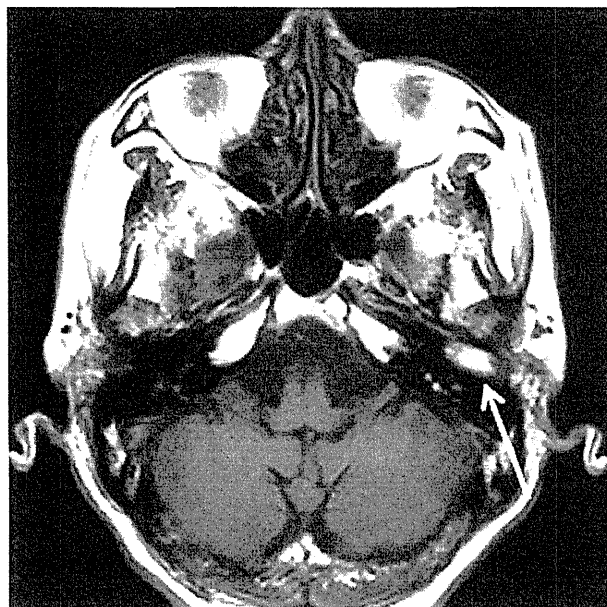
A routine T1-weighted axial image with 5 mm thickness. Cerumen impaction is visualized as a high signal intensity structure similar to fat (arrow).
